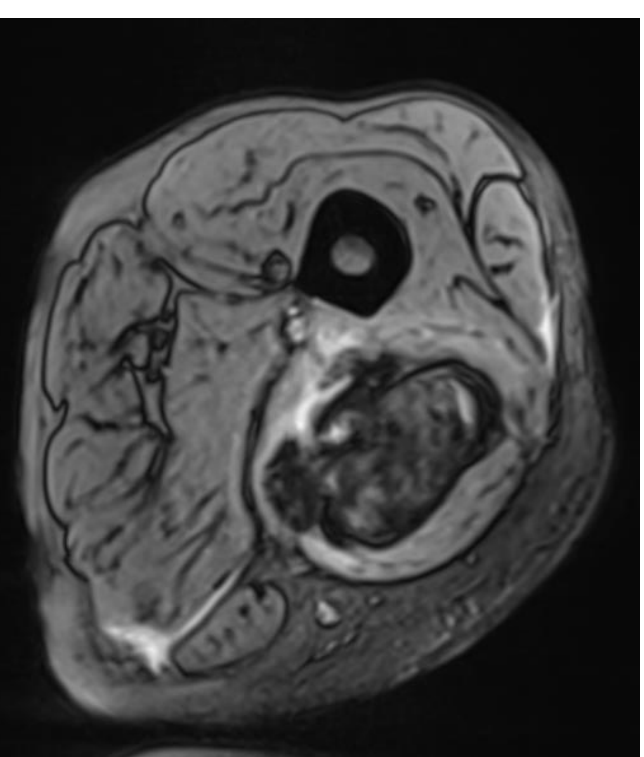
MRI, Large haemorrhagic mass invading vastus medialis
